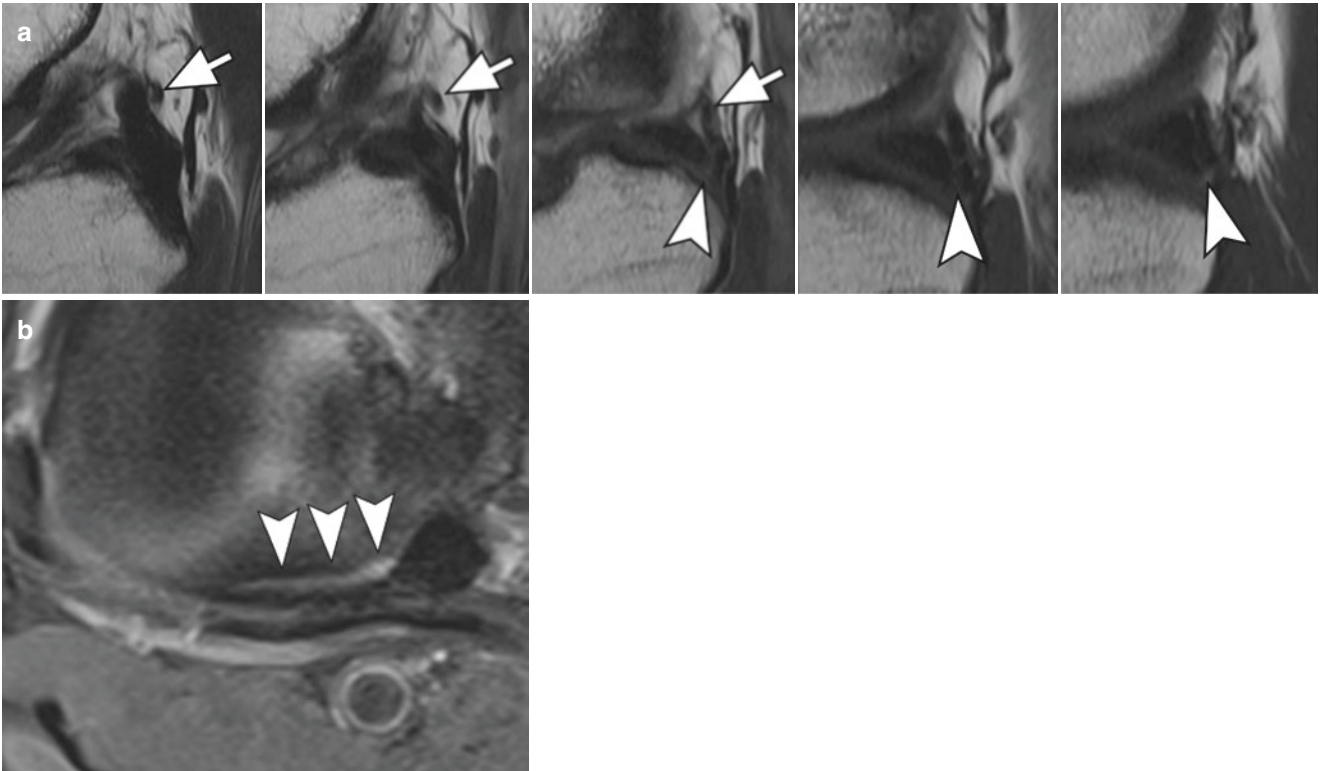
Zip lesion. (a) Consecutive sagittal PD-weighted images and (b) axial T2-weighted image show the Wrisberg ligament inserting in the posterior horn of the lateral meniscus (arrows) and a peripheral vertical longitudinal tear of this meniscus (arrowheads)
